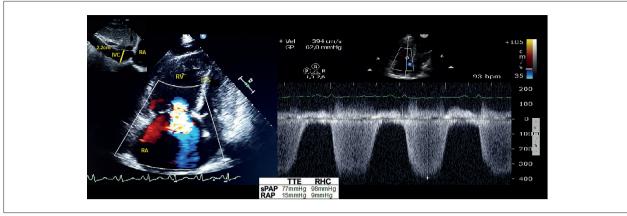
Disagreement between systolic pulmonary artery pressure and right atrial pressure measured through TTE and RHC in a patient with Schistosomiasisassociated pulmonary hypertension. IVC: inferior vena cava; IVS: interventricular septum; RA: right atrium; RHC: right heart catheterization; RV: right ventricle; sPAP: systolic pulmonary arterial pressure; TTE: transthoracic echocardiogram.
